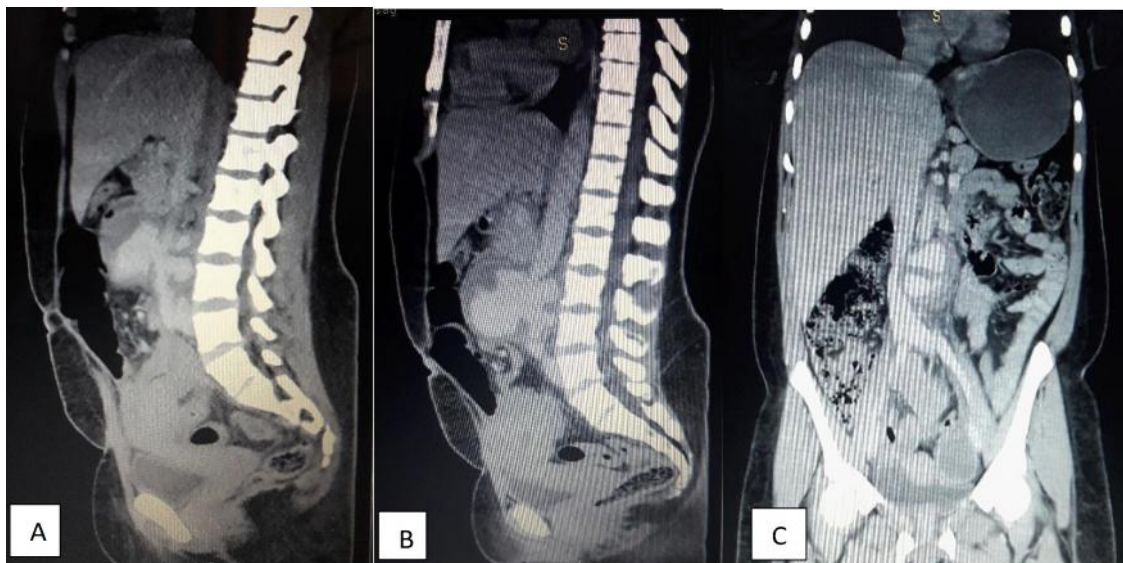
(A&B) Sagittal views of contrast enhanced CT of the abdomen (arterial phase) of a 37-year-old female showing multiple anterior and posterior saccular aneurysms. The eccentric filling defect on the anterior aneurysm is a thrombus. (C) Coronal view shows the compression of the inferior vena cava by an aneurysm
